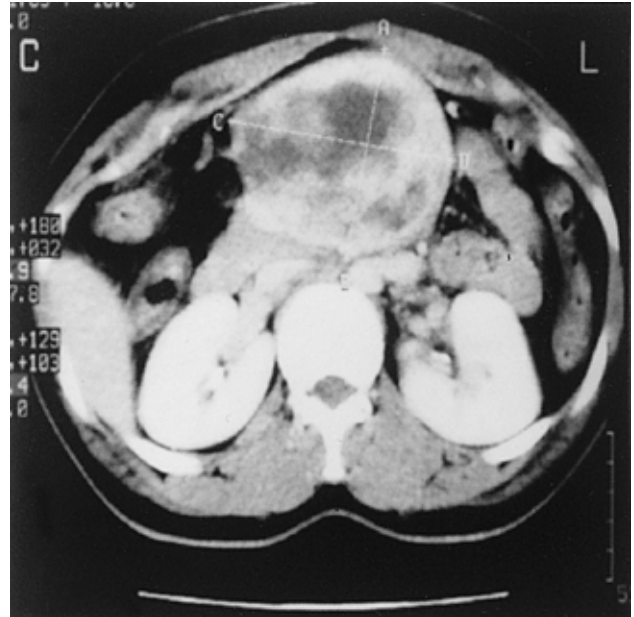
Abdominal CT scan of case I demonstrating a large (approximately 9×10 cm) inhomogeneous mass with an area of central necrosis.
